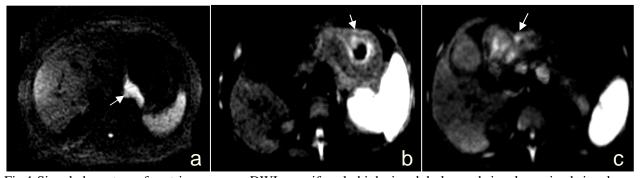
Signal characters of gastric cancer on DWI. a, uniformly high signal. b, layered signal. c, mixed signal.
